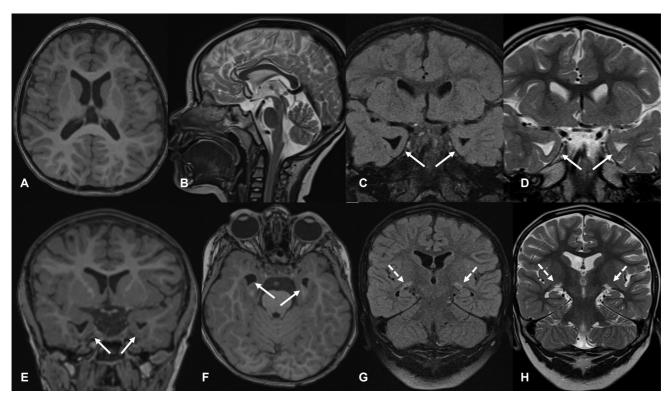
Dedicated brain magnetic resonance imaging (MRI) obtained at the age of 4 years. (A) Axial T1 shows mild ventriculomegaly with paucity of the white matter. (B) Sagittal T2 shows microcephaly with normal midline structures but mild hypoplasia of the sella and pituitary gland. Oblique coronal fluid-attenuated inversion recovery (FLAIR) (C), T2 (D), T1 (E), and axial T1 (F) shows asymmetrically dilated temporal horns with absent subcortical U-fibers immediately underneath the entorhinal and perirhinal cortex of the ventral parahippocampal gyri (solid white arrows), different than rest of the brain. Oblique coronal FLAIR (G) and T2 (H) slices show bilateral circumscribed T2 hyperintense white matter lesions in the vicinity of bilateral Meyer's loop of the optic radiation (dashed white arrows).
